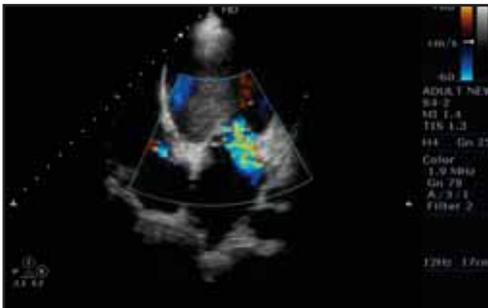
Echocardiography showing moderate Mitral Regurgitation
